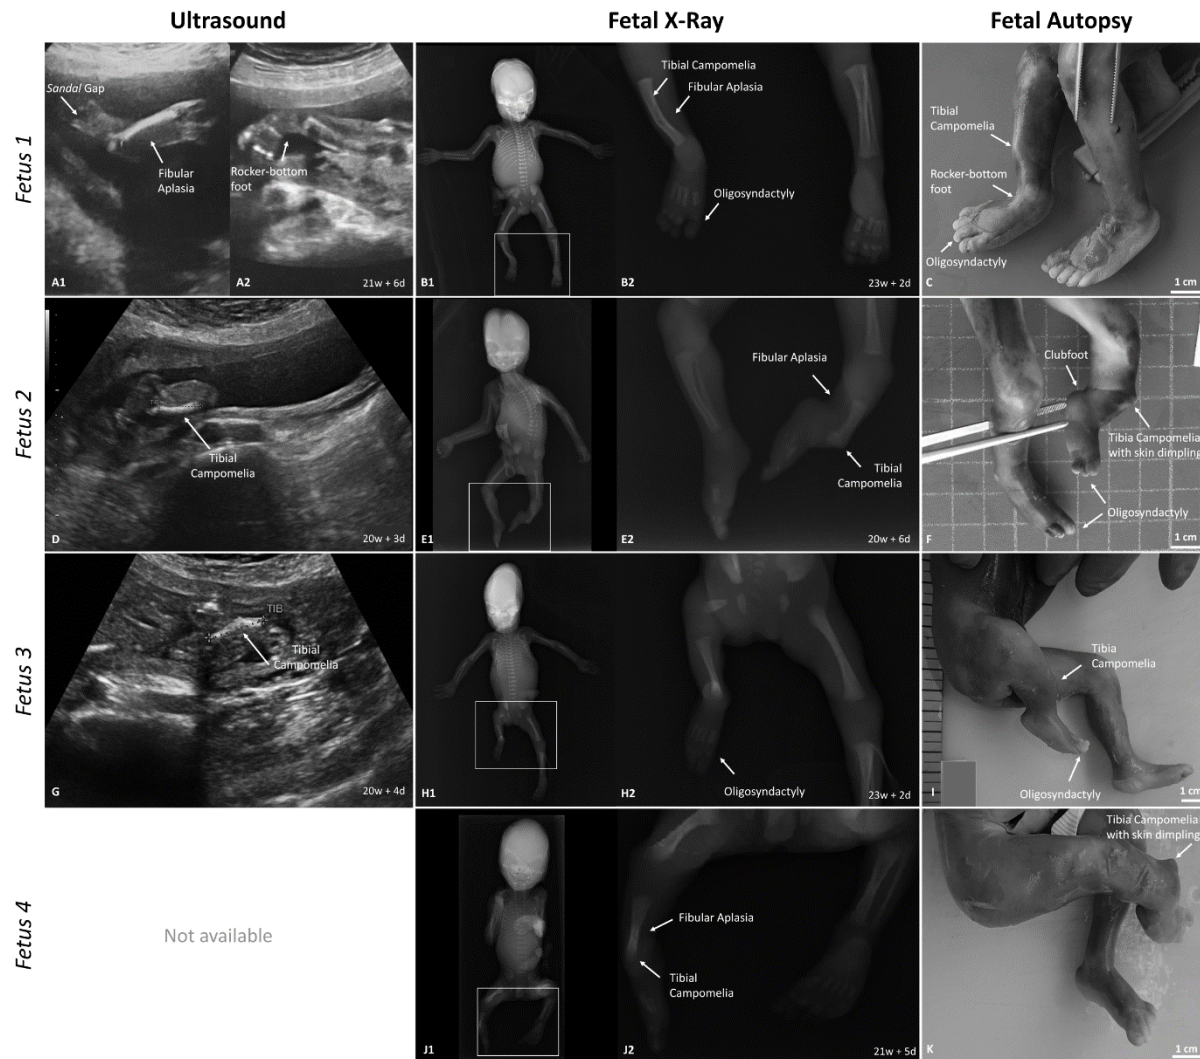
Image documentation of ultrasound (A1-A2, D and G), fetal X-Ray (B1-B2, E1-E2, H1-H2 and J1-J2) and fetal autopsy features (C, F, I and K) of the four fetuses presented in this study, demonstrating key features of FATCO syndrome, such as fibular aplasia, tibial campomelia and oligosyndactyly. Ultrasound imaging of the right lower limb of fetus 4 demonstrating key features of FATCO was not available.
